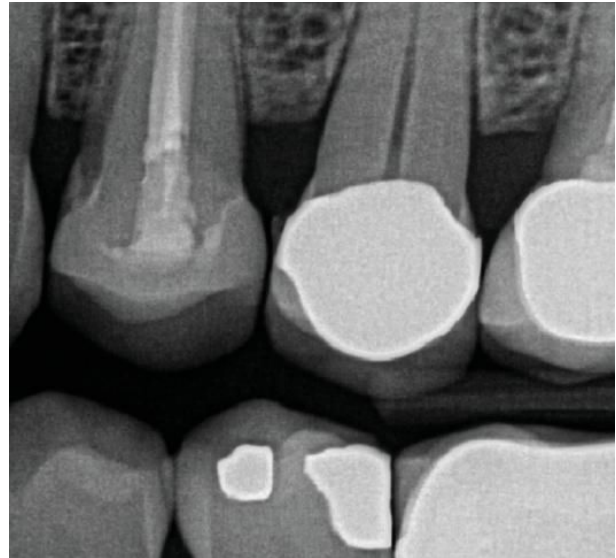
Final radiograph tooth #12 fast grind
